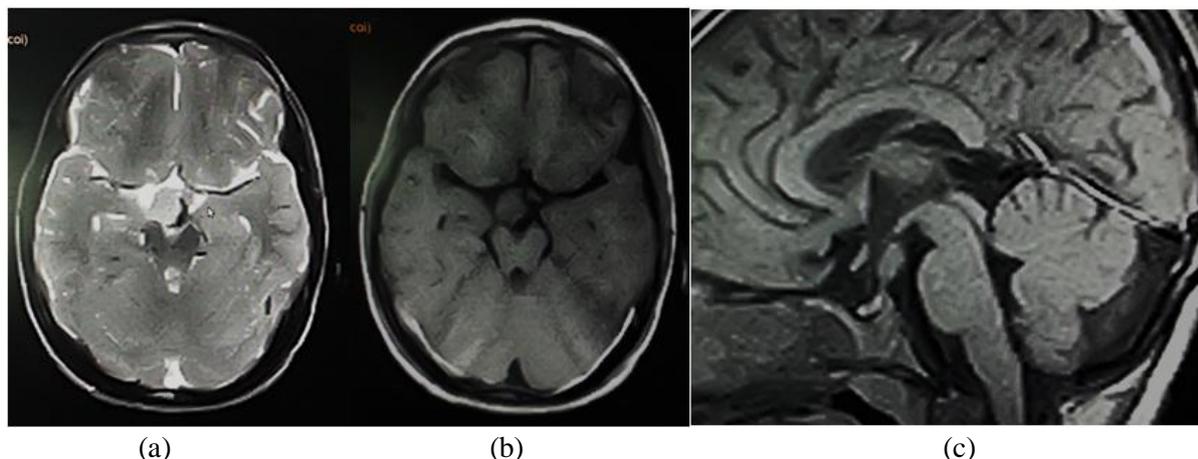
A 5- year- old boy with aggressive antisocial behavior and hyperactivity. a) Axial FLAIR and b) Axial T1WI show an isointense signal lesion at the right side of mid line filling the right side of the supra-sellar cistern. c) Sagittal T1WI showed markedly thickened tuber cinereum. Note the normal girth and segmentation of corpus callosum (Final diagnosis hamartoma of tuber cinereum).
